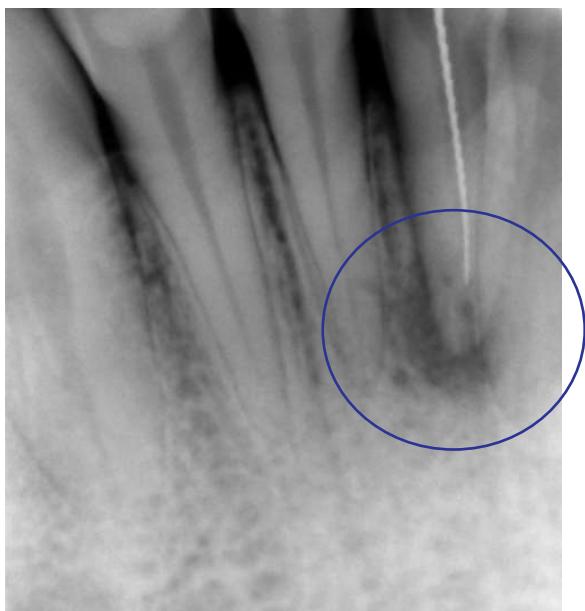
Radiographic image obtained during working length determination. The image shows the root canal during conductometry, with an initial reduction of the infected periapical area.
